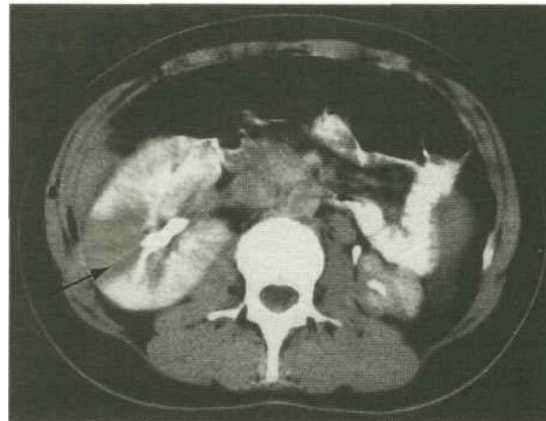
CT scan showing a wedge-shaped area of renal cortical loss (arrow) following acute pyelonephritis.
